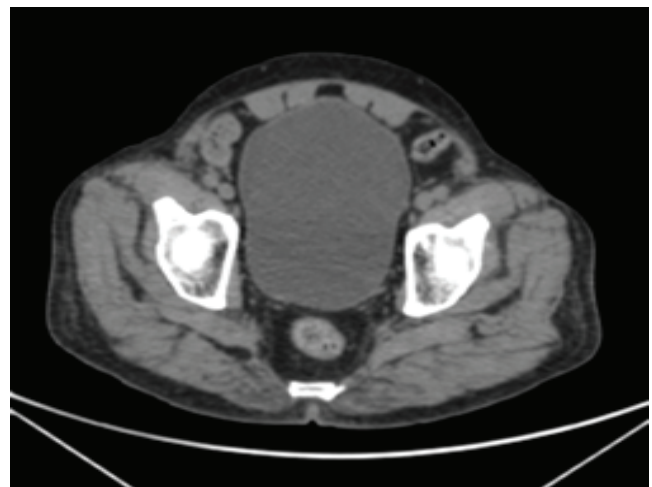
(a): CT image in axial section showing no anatomical lesion within the UB
